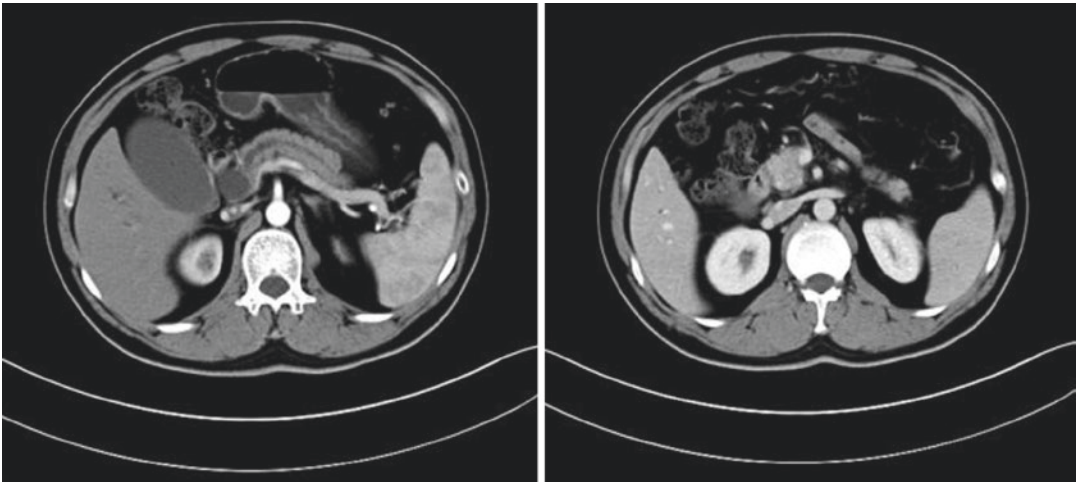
CT images showed a mass in the head of the pancreas with infiltration of the portal vein
